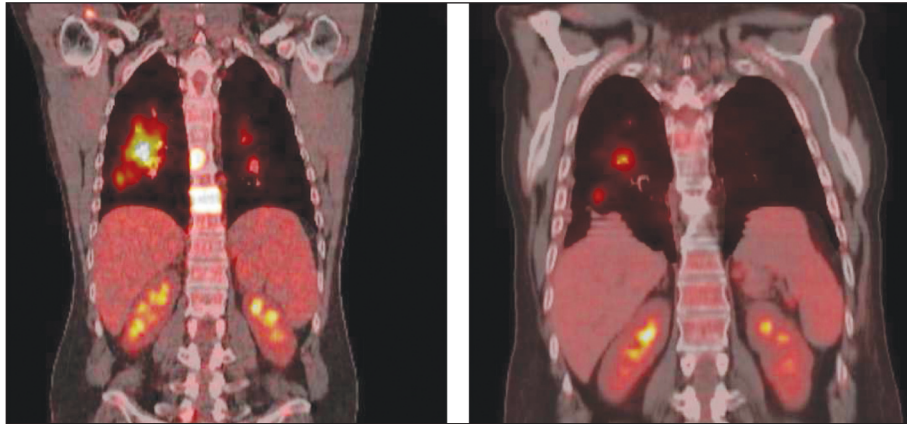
PET-CT before treatment (left) and after treatment (right). The FDG uptake decreased significantly after treatment. These findings are correlant with the beta-hCG levels before and after treatment.
